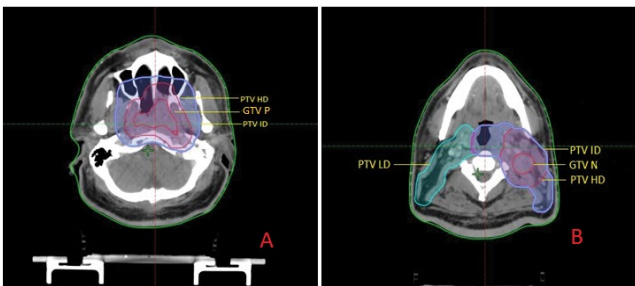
(A) Axial section of planning CT scan image at the level of nasopharynx showing planning target volumes (PTV). (B) Axial section of planning CT scan image at the level of gross nodes showing PTVs. PTV HD- High Dose PTV, PTV ID -intermediate dose PTV, PTV LD-low dose PTV, GTV P- gross tumour volume primary, GTV N- gross tumour volume nodes
